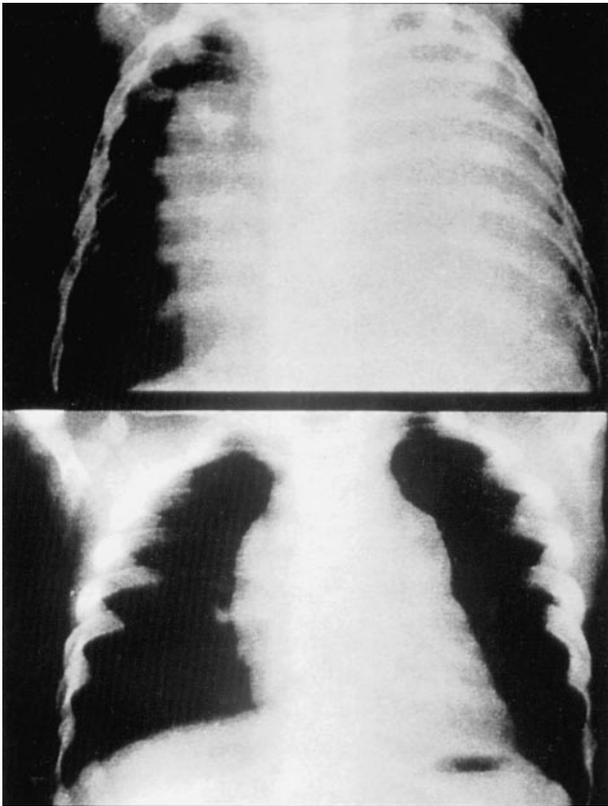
Preoperative chest radiograph of a 6-month-old with a huge pleural cyst (top). Postoperative course was quite uneventful (bottom).
